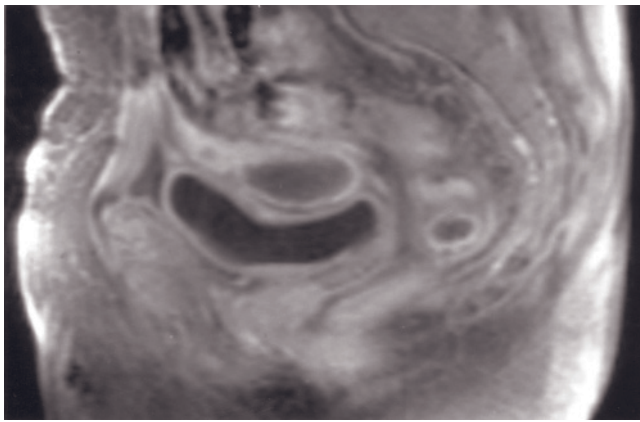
(*Continued*) and bladder walls are thickened, and a fistula between the bladder and vagina (arrow, *d*) is apparent. Sagittal-plane, T1-weighted gadolinium-enhanced fat-suppressed images are particularly effective at demonstrating fistula between female pelvic organs and the bladder. Substantial submucosal edema of the bladder is appreciated as high signal on T2 (arrow, *a*) and lack of enhancement on postgadolinium images (*d*). Sagittal T2-weighted single-shot echo-train spin-echo (*e*) and sagittal (*f*) and transverse (*g*) T1-weighted gadolinium-enhanced fat-suppressed SGE images in a second patient with cervical cancer after radiation therapy. Enlarged tissue in the region of the cervix is heterogeneous on T2- and hypointense on postgadolinium T1-weighted images (*f*, *g*), consistent with cervical necrosis. The necrotic tissue is in continuity with the posterior bladder wall, and a low-signal-intensity fistulous tract is apparent on sagittal and transverse images (arrows, *f*, *g*). Sagittal T2-weighted single-shot
